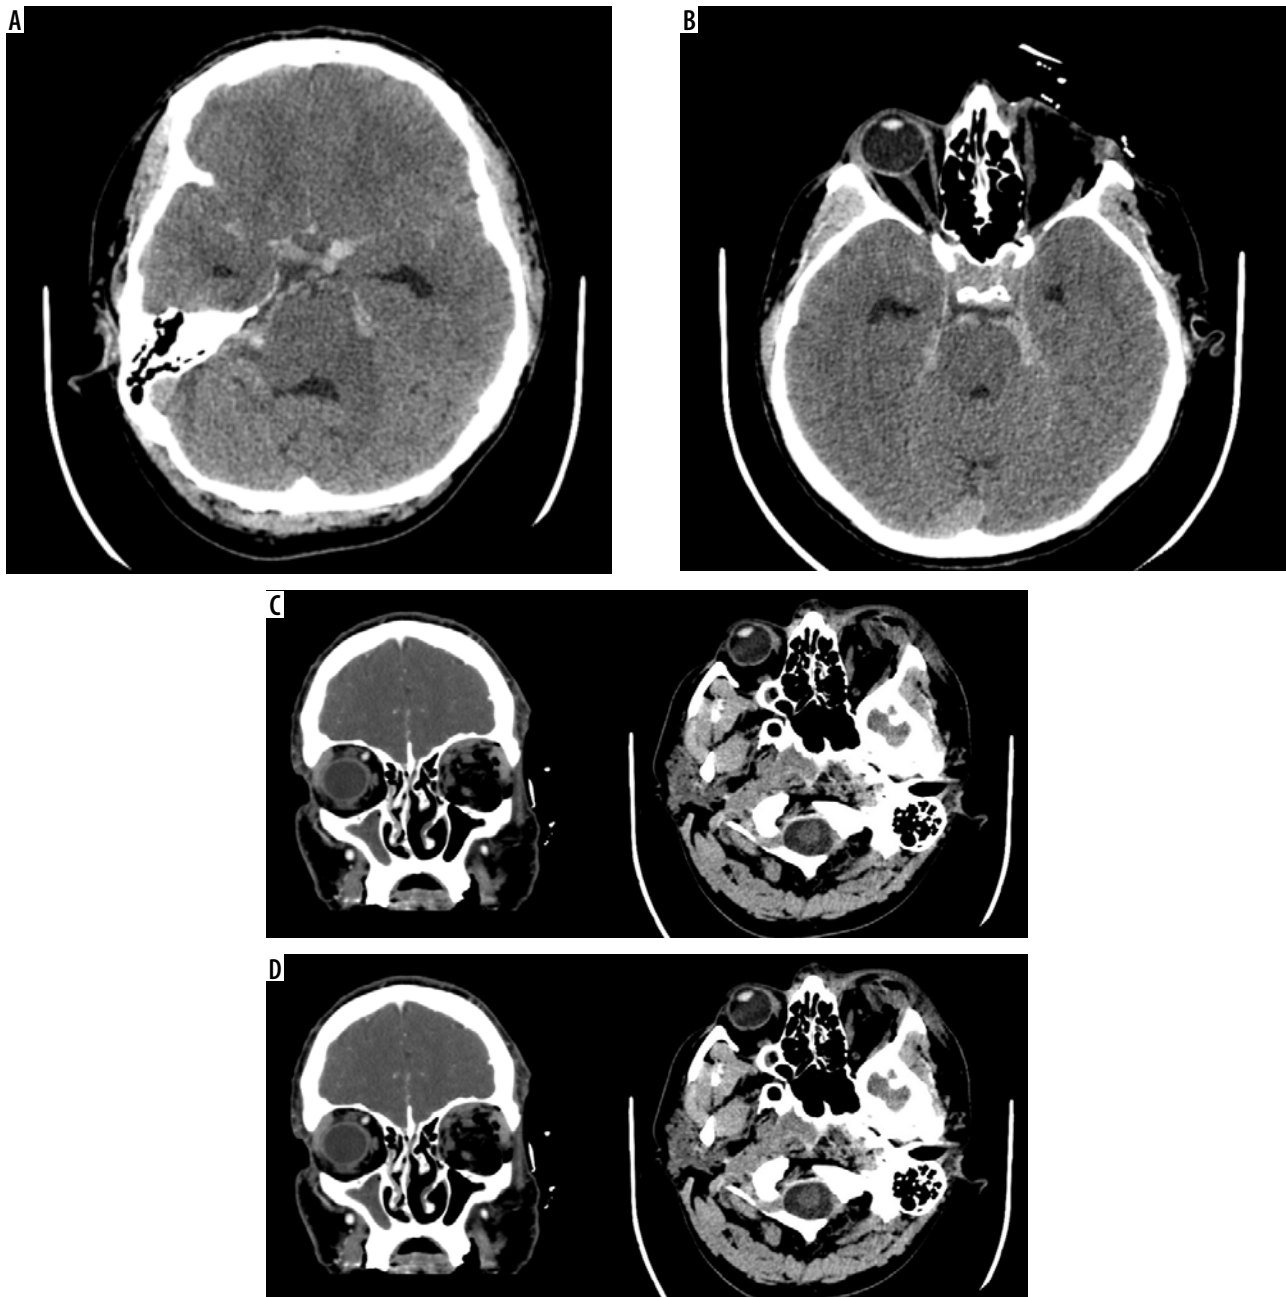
Oedipism: computed tomography showing: lack of the left eyeball, bleeding both in subarachnoid space and in spaces and structures of the brain
